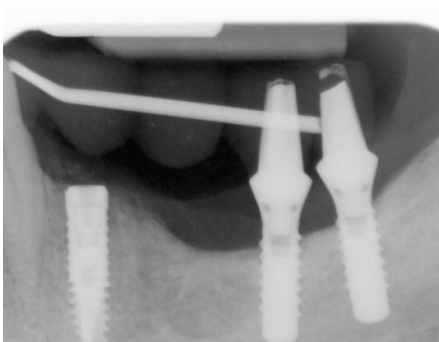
Post-implant placement radiograph.
